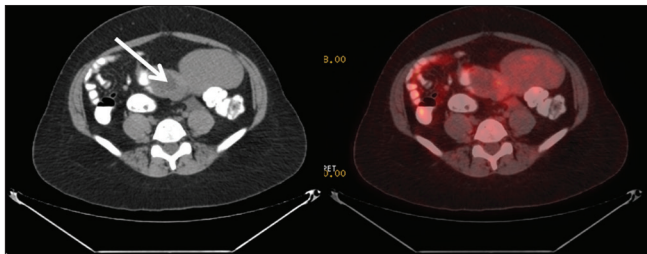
Axial PET/CT images of pelvis showing non-FDG enlarged ovary with cystic areas adherent to the pelvic mass (arrow)
